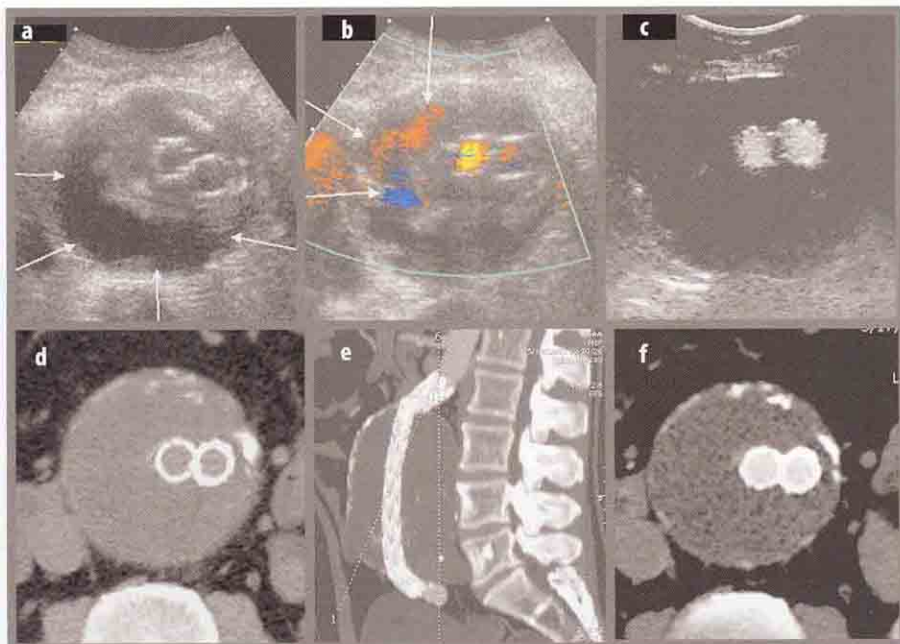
Endotension.* a US baseline. Large sac with inhomogeneous and 'fluid' thrombus; strong hyperechoic structures correspond to endoprosthesis iliac branches. b Colour Doppler scan. Colour signals in iliac prosthetic branches; inside the residual thrombosed aneurysmatic sac, there is a chromatic signal (*white arrows*), not easily interpretable (possible flow or artefact?). c CEUS. The iliac branches enhance with contrast microbubbles; in the sac no hyperechoic sign due to contrast bubbles is detectable. d-f Spiral CT. Absence of contrast inside the aneurysmatic sac in early and late phase. No endoleak is evident
